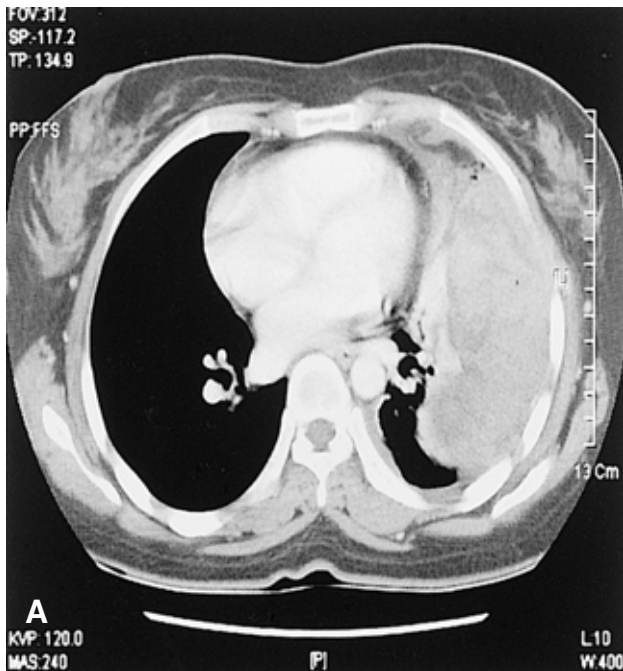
Chest CT scan of case II shows an inhomogeneous mass and a large amount of a left pleural effusion.
